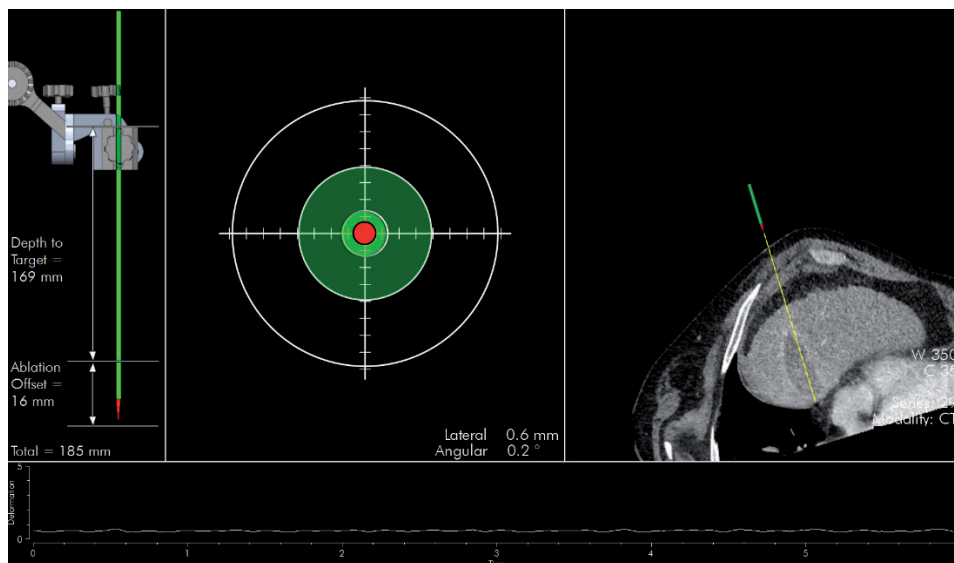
Crosshair viewer with the orientation and depth aid for accurate placement and a real-time CT slice along the current trajectory.
